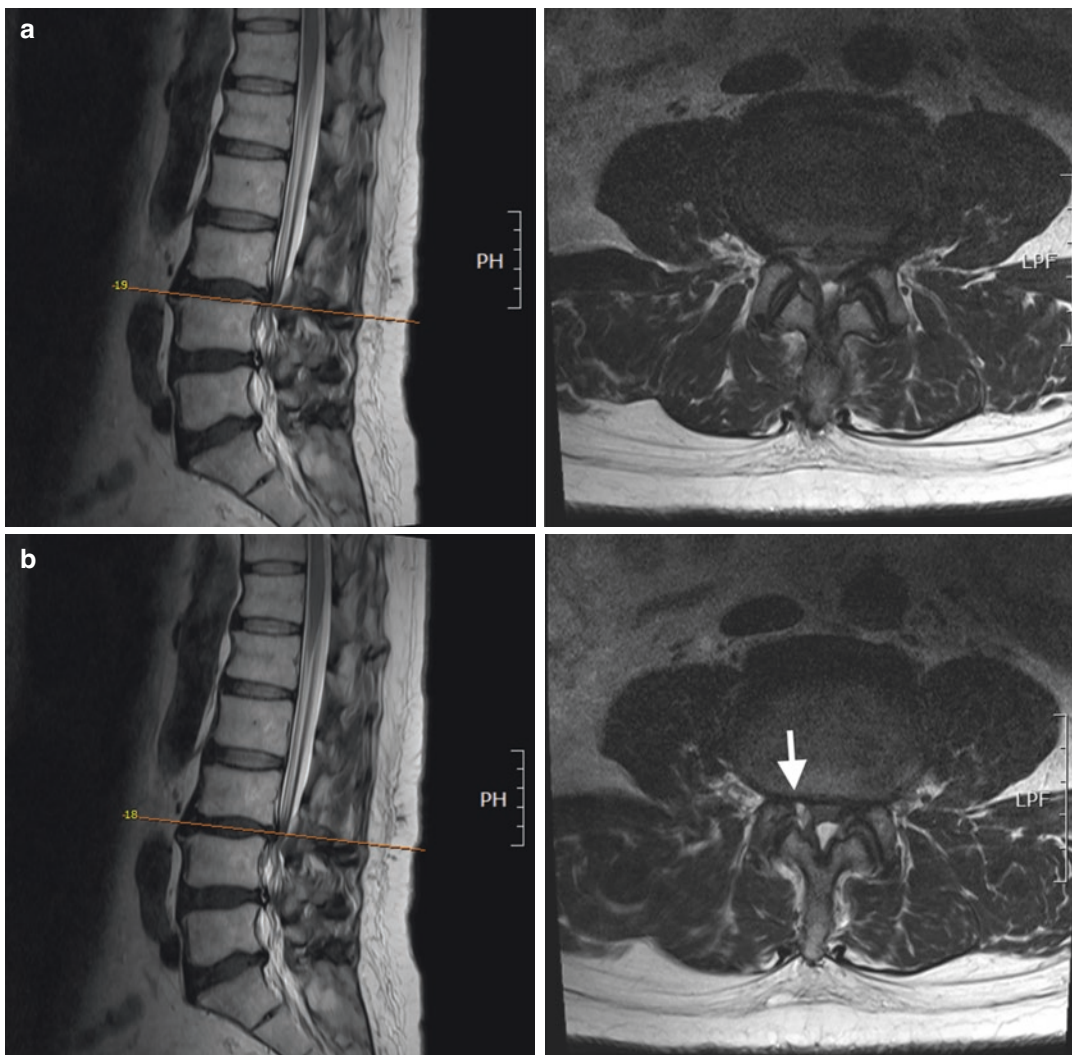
Preoperative MRI (a) shows central canal stenosis and (b) a right facet joint cyst (arrow)
